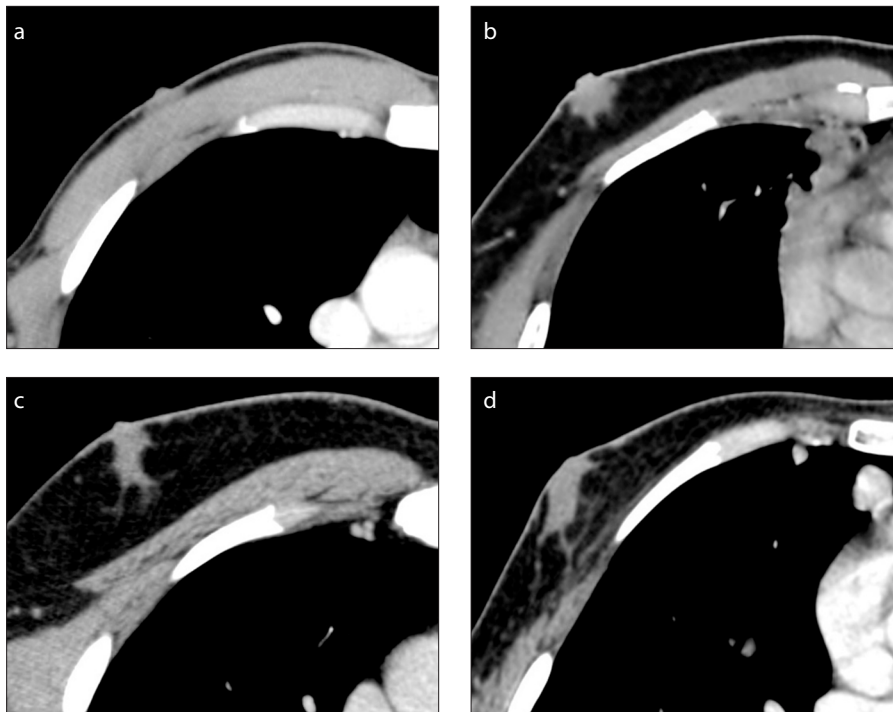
a–d. CT classification of breast glandular tissue. Examples of patients without gynecomastia (a) and nodular (b), dendritic (c), and diffuse (d) types of gynecomastia are shown.
